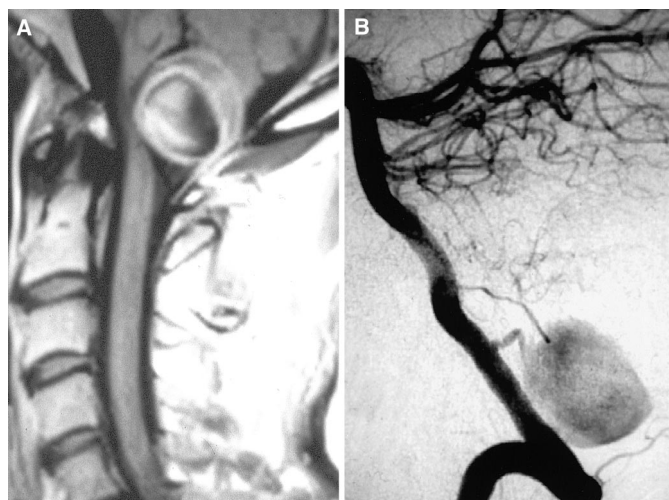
Patient 3. A, sagittal T1-weighted magnetic resonance imaging scan revealing heterogeneous signal within a giant PICA aneurysm. B, lateral vertebral arteriogram revealing the giant aneurysm that was treated by occipital artery-PICA bypass, then trapping and excision of the aneurysm.
